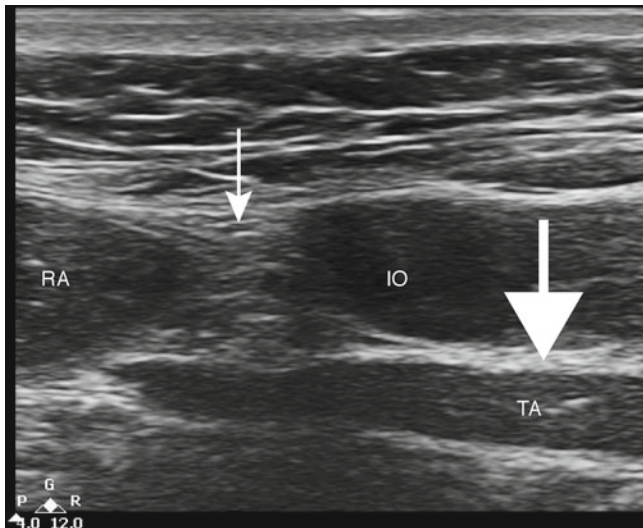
Linea semilunaris under ultrasound. Linea semilunaris (*white arrow*), rectus abdominis (*RA*), internal oblique (*IO*), transversus abdominis (*TA*), transversus abdominis plane (*bold white arrow*)
